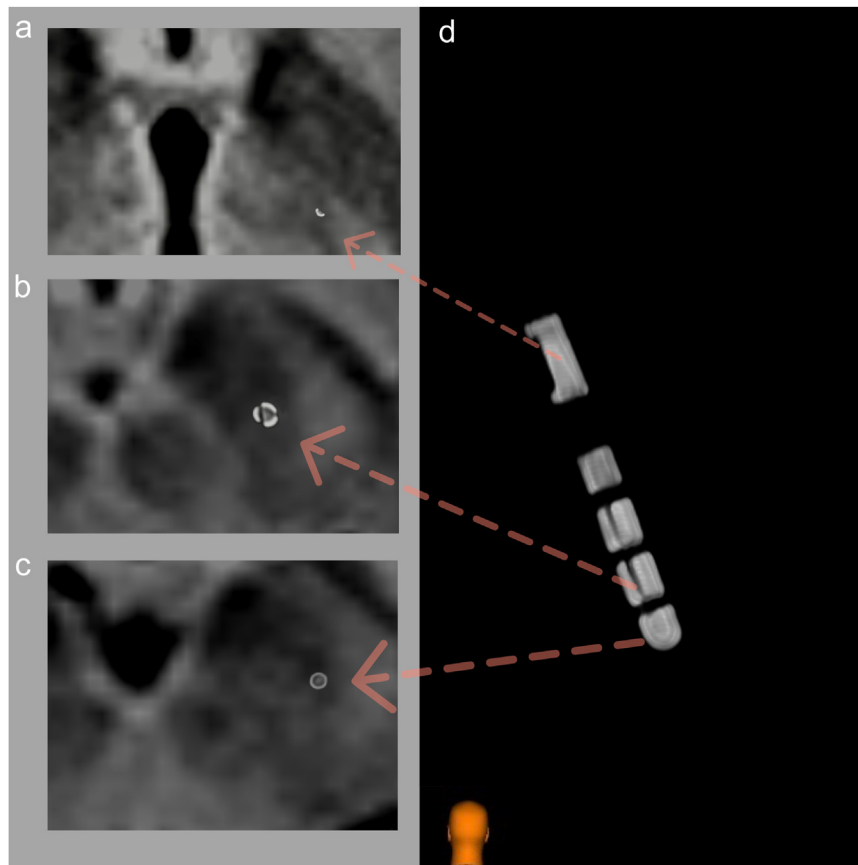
Boston Cartesia DB-2202 to subthalamic nucleus target. A 3D rendering of a directional electrode in the left subthalamic nucleus, with corresponding axial slices through directional marker, lower segmented, and ring contacts (all fused to preoperative axial MRI fluid-attenuated inversion recovery [FLAIR]). It can be immediately appreciated, both from the mannequin and the axial slice through the directional marker, that the lead is oriented posteromedially. [Color figure can be viewed at www.neuromodulationjournal.org]
